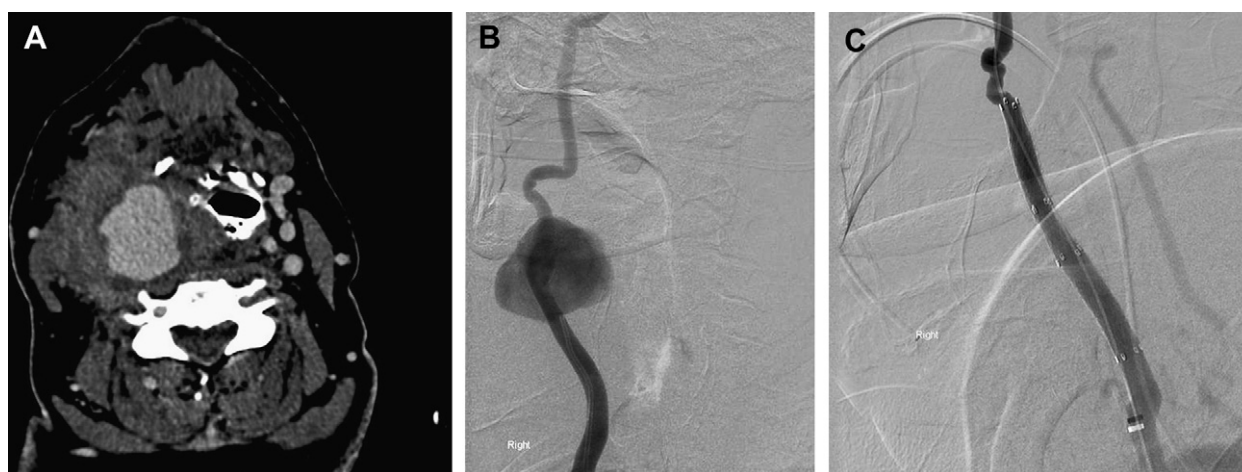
(A) CT angiogram showing the pseudoaneurysm at the carotid bifurcation. (B) Diagnostic carotid angiogram confirming pseudoaneurysm. (C) Angiogram showing successful endovascular exclusion of the right carotid pseudoaneurysm.
